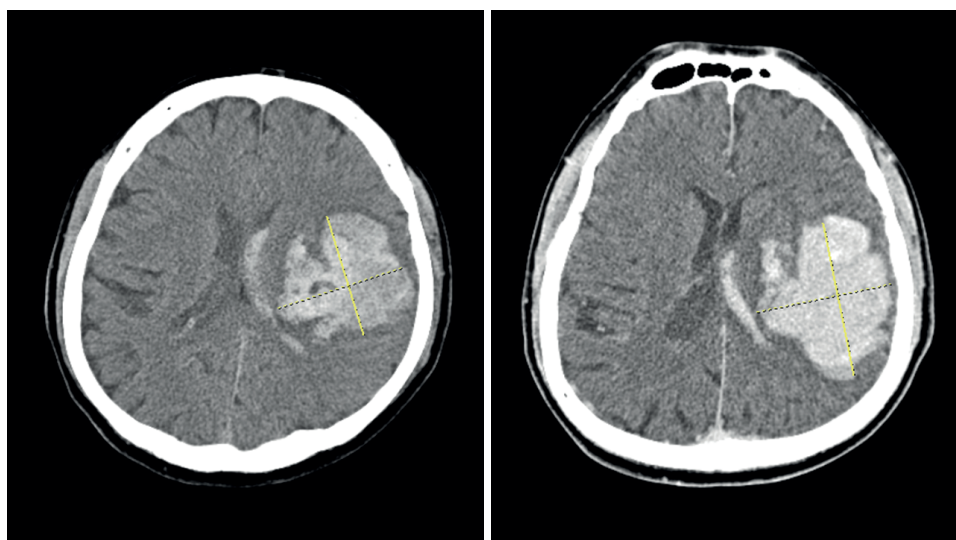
A patient exhibiting a low sphericity index (1.04) on the initial CT scan displayed hematoma expansion in the preoperative follow-up CT scan; the sphericity index still remaining low (1.18).
